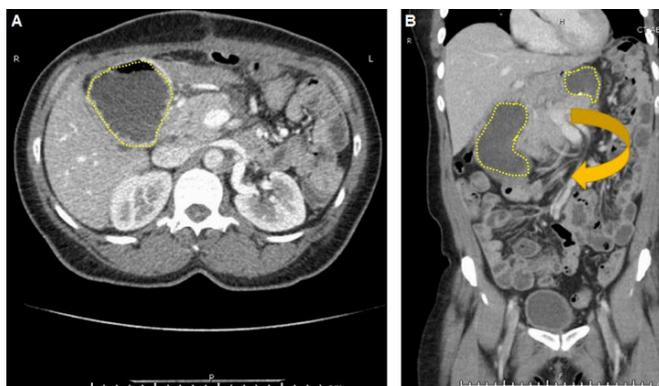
A CT scan of the patient on the day of her presentation to a routine clinic appointment, 13 days after her laparoscopic DPS. A: On transverse sections of the CT scan, the stomach is seen to be abnormally present on the right side of the abdomen (yellow-dashed line). B: On coronal sections of the CT scan, the stomach is imaged with both the cranial portion visible to the left of midline and the caudal portion visible to the right of the midline (both outlined in yellow dashes) with an arrow denoting the direction of volvulus.
